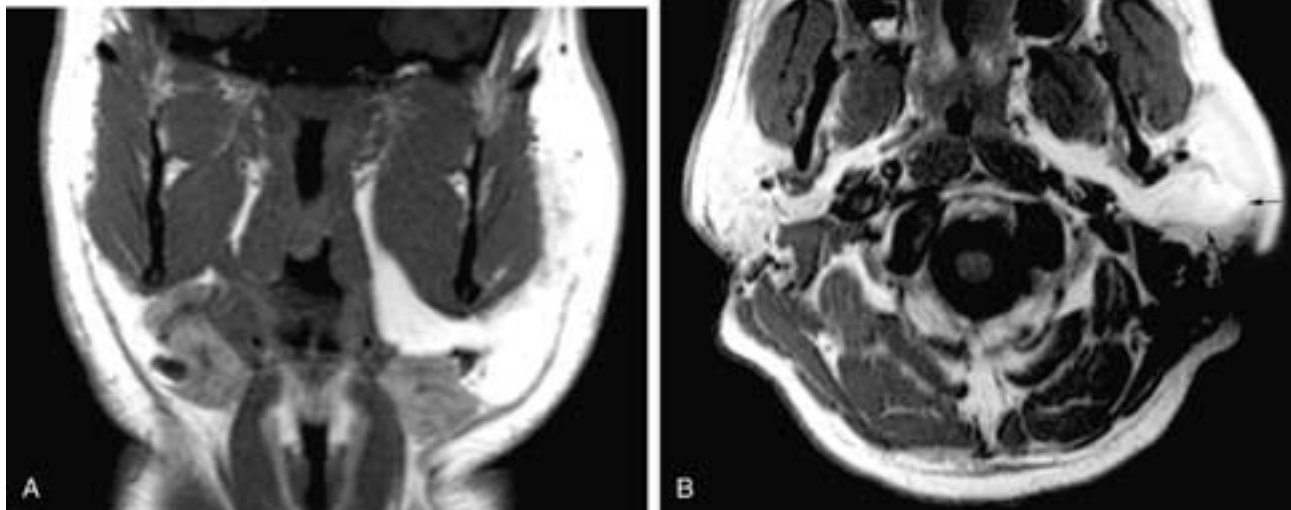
Coronal (A) and axial (B) MR images show a fat signal intensity mass filling and expanding the left parapharyngeal space and extending well into the left parotid gland (arrows in B). This was a benign lipoma.
